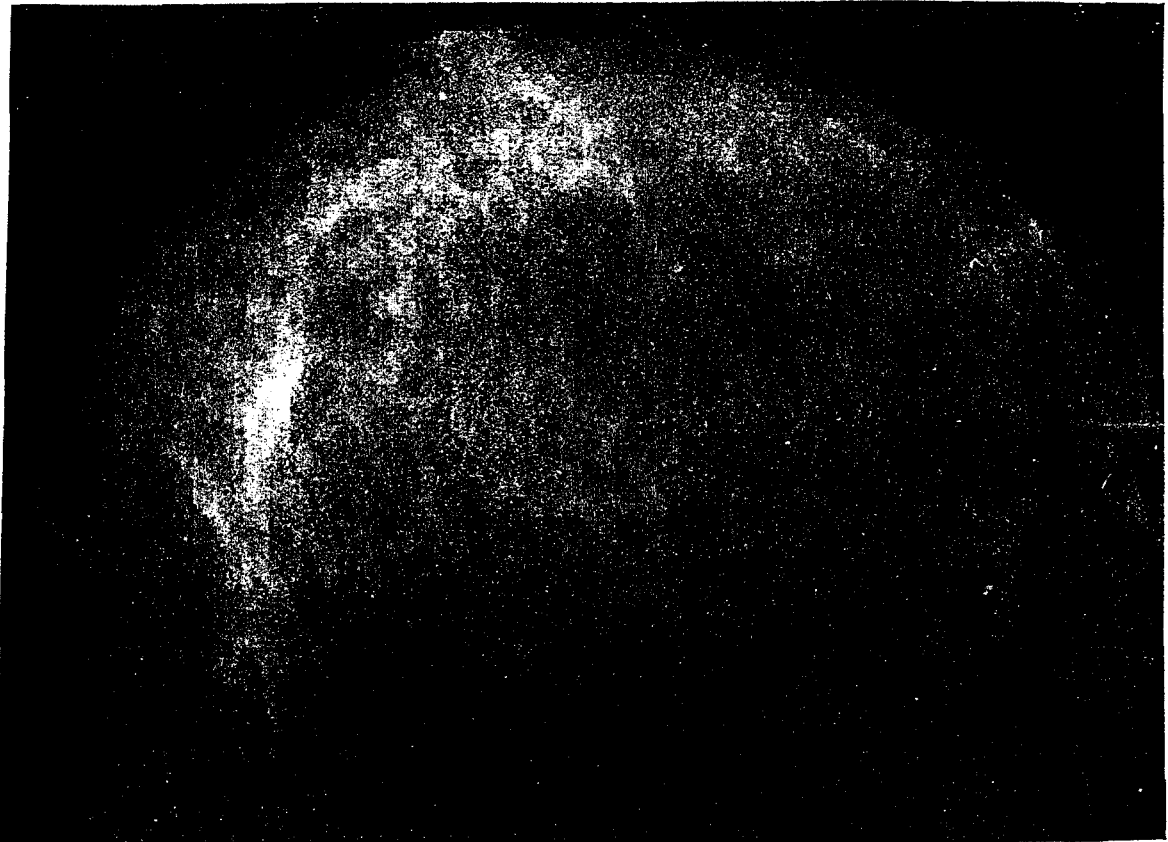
(a) Left breast, x-ray image.
